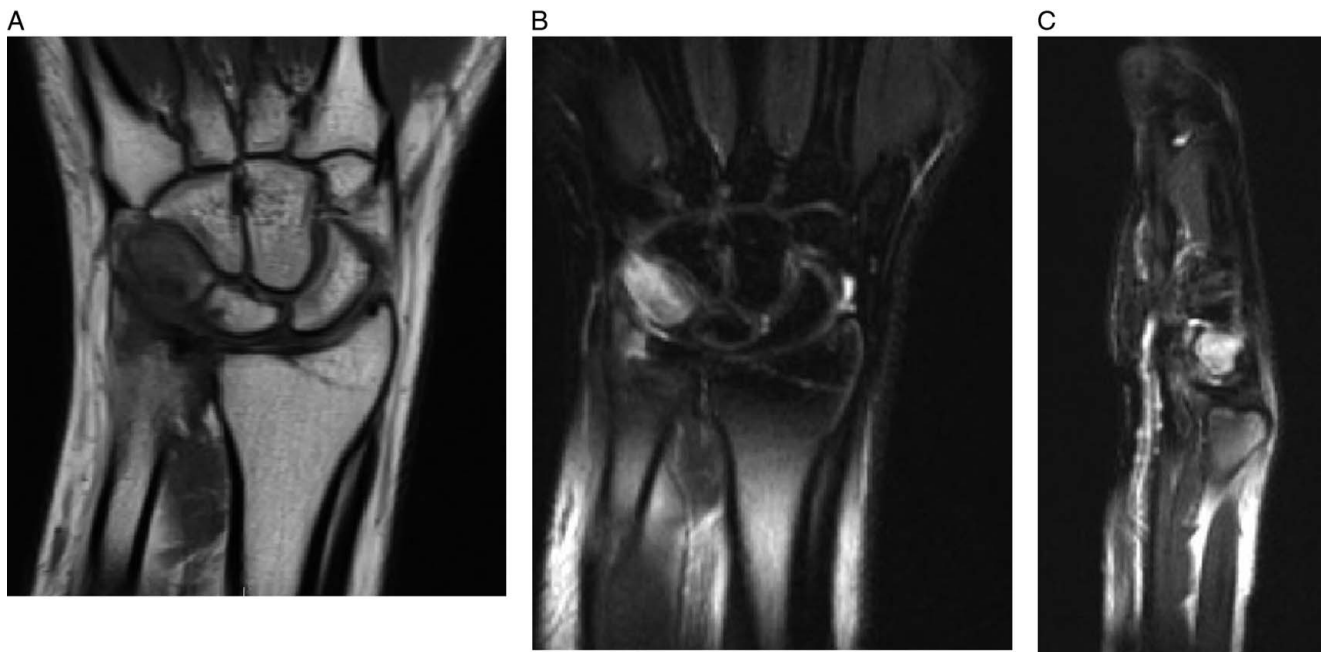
(A) T1 MRI coronal view of the right wrist shows increased signal intensity in the triquetrum. (B) T2 MRI coronal view of the right wrist shows increased signal intensity in the triquetrum. (C) T1 MRI sagittal view of the right wrist shows increased signal intensity in the triquetrum.
